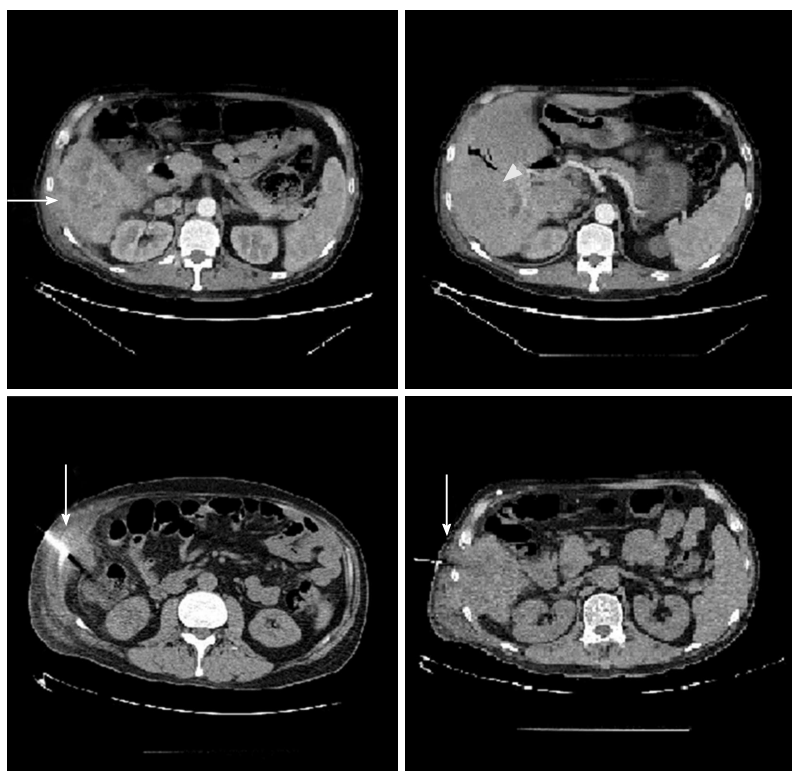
Computed tomography scan images of the liver. The vertical white arrows show the site of needle biopsy. The horizontal white arrow shows tumour mass in S5 extending to S6 and the arrow head shows the site of right intrahepatic duct dilatation.
